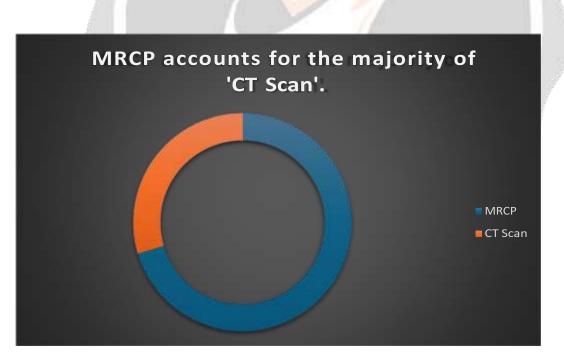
MRCP versus CT scan.
